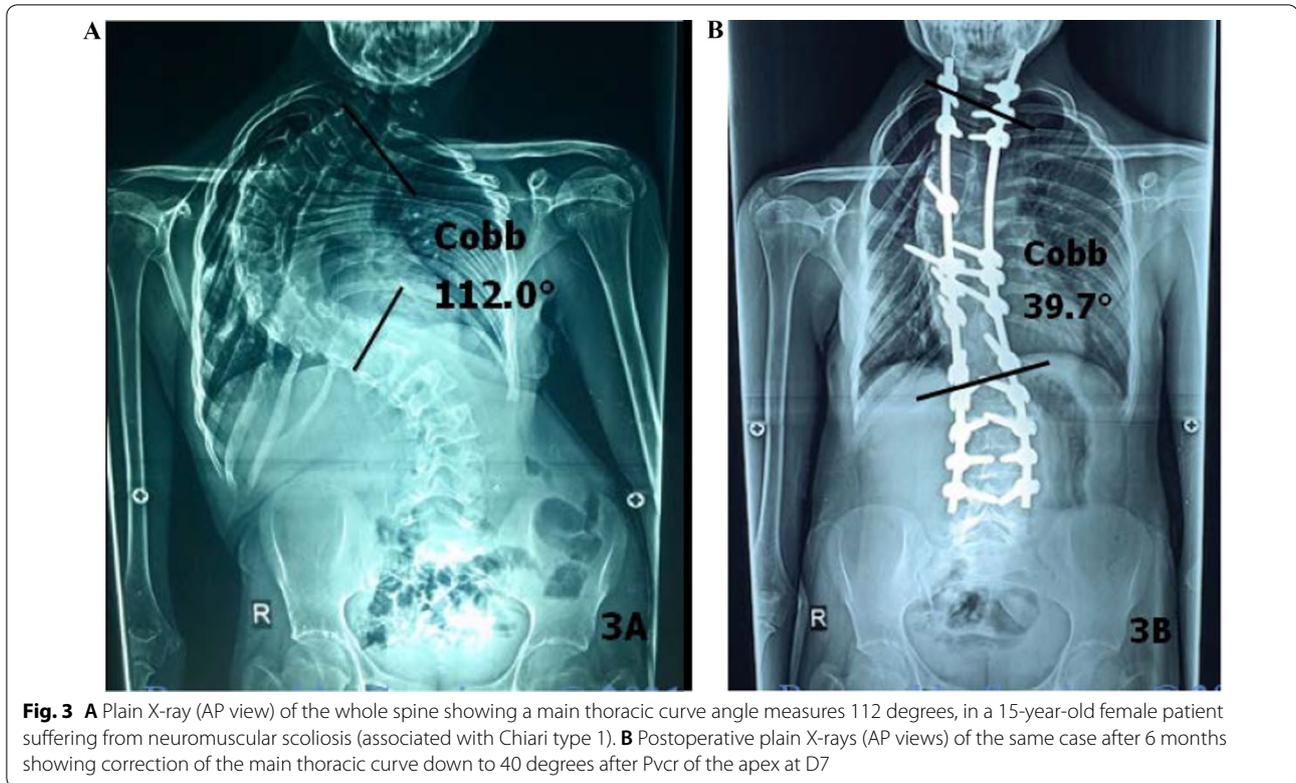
A Plain X-ray (AP view) of the whole spine showing a main thoracic curve angle measures 112 degrees, in a 15-year-old female patient suffering from neuromuscular scoliosis (associated with Chiari type 1). B Postoperative plain X-rays (AP views) of the same case after 6 months showing correction of the main thoracic curve down to 40 degrees after Pvcr of the apex at D7
